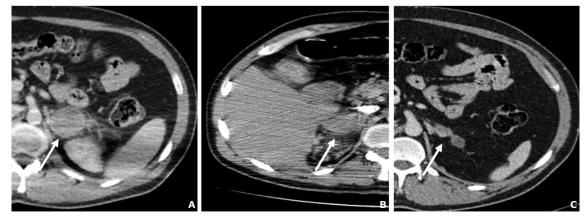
A) Adrenal computed tomography (CT) at admission to the emergency department (43 mm left adrenal mass, perirenal hemorrhage). B) Adrenal CT at admission to the emergency department (right adrenal hematoma). C) Adrenal CT taken one year later (7 mm nodular lesion in left adrenal).
